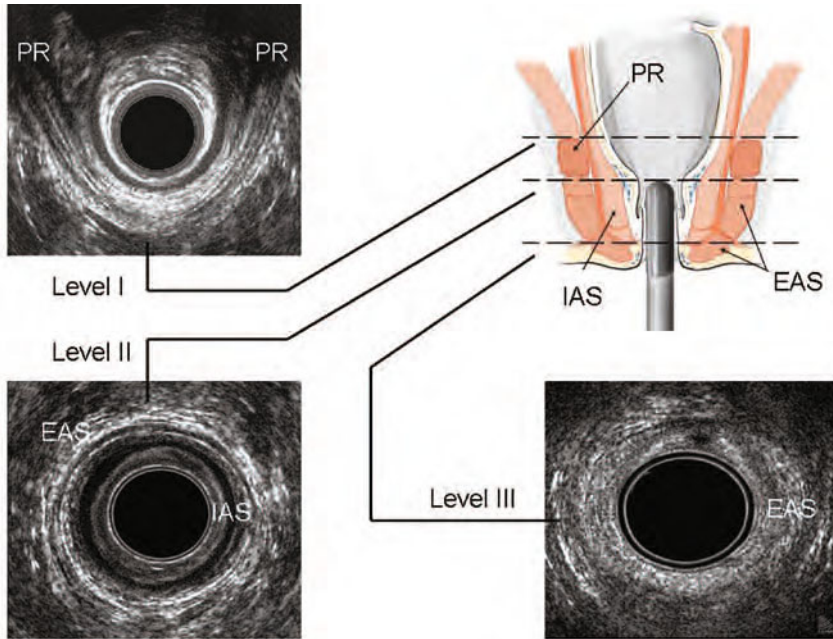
Three-dimensional endoanal ultrasonography. Three standard levels of assessment of the normal anal canal: levels I–III. *EAS*, external anal sphincter; *IAS*, internal anal sphincter; *PR*, puborectalis muscle. (Reproduced from [10], with permission)
